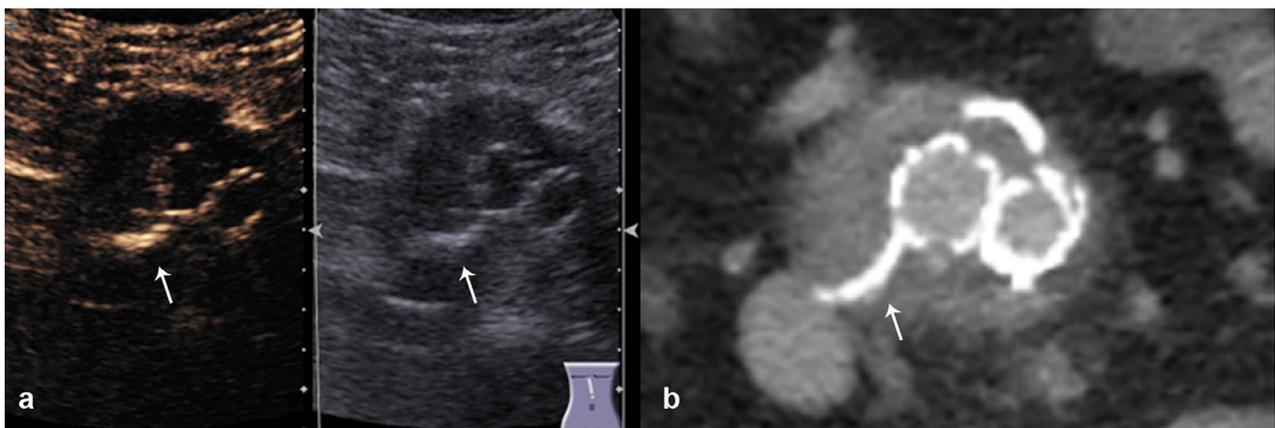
False positive: Insonation of embolization material. (a) Interaction of contrast mode imaging with embolization material (coils and tissue adhesive, arrow), creating hyperechoic artifacts on contrast-enhanced ultrasound after occlusion of lumbar arteries bilaterally and inferior mesenteric artery for treatment of endoleak II. The artifact in the figure's lower left region is more easily visible because of the greater discontinuity in acoustic impedance. (b) Correlation with computed tomography angiography validates the absence of endoleaks.
